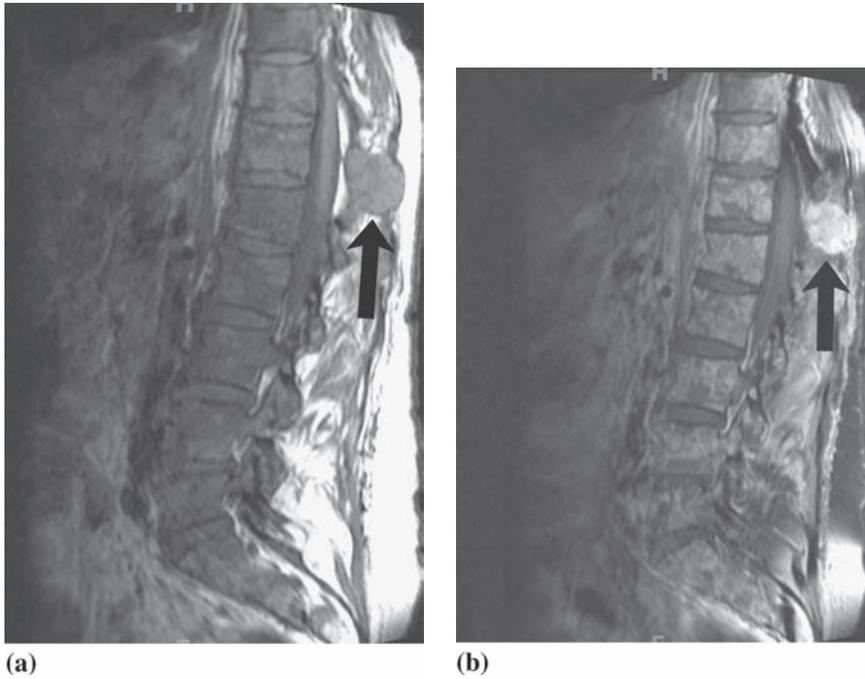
Diffuse breast cancer metastasis with soft tissue component. (a) Sagittal T1-weighted MR image shows diffuse decreased signal of the vertebrae that is almost isointense with the intervertebral discs. There is posterior soft tissue mass at T12 level (arrow). (b) Contrast-enhanced fat-saturated sagittal T1-weighted image demonstrates heterogenous enhancement of the vertebrae and the metastatic soft tissue mass (arrow)
